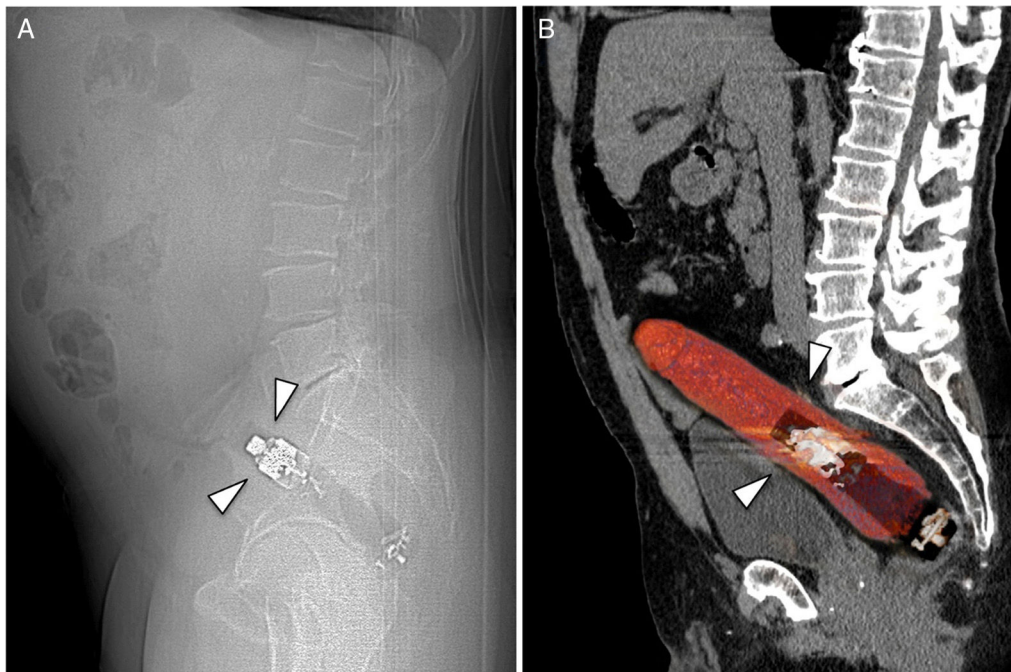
(A). Lateral view of a conventional abdominal x-ray that demonstrates the presence of a foreign body with a metal component, inserted into the rectum (arrowheads). (B). Sagittal reconstruction of an abdominal computed tomography scan that confirmed the presence of the foreign body with metal and plastic components, situated inside the rectum (arrowheads).
